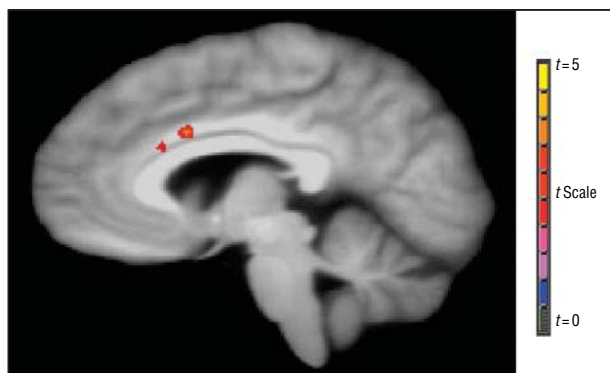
Fractional anisotropic reductions in patients with obsessive-compulsive disorder vs healthy comparison subjects in the left hemisphere anterior cingulate white matter rendered onto a T1-weighted image (threshold $t=3.05$).
